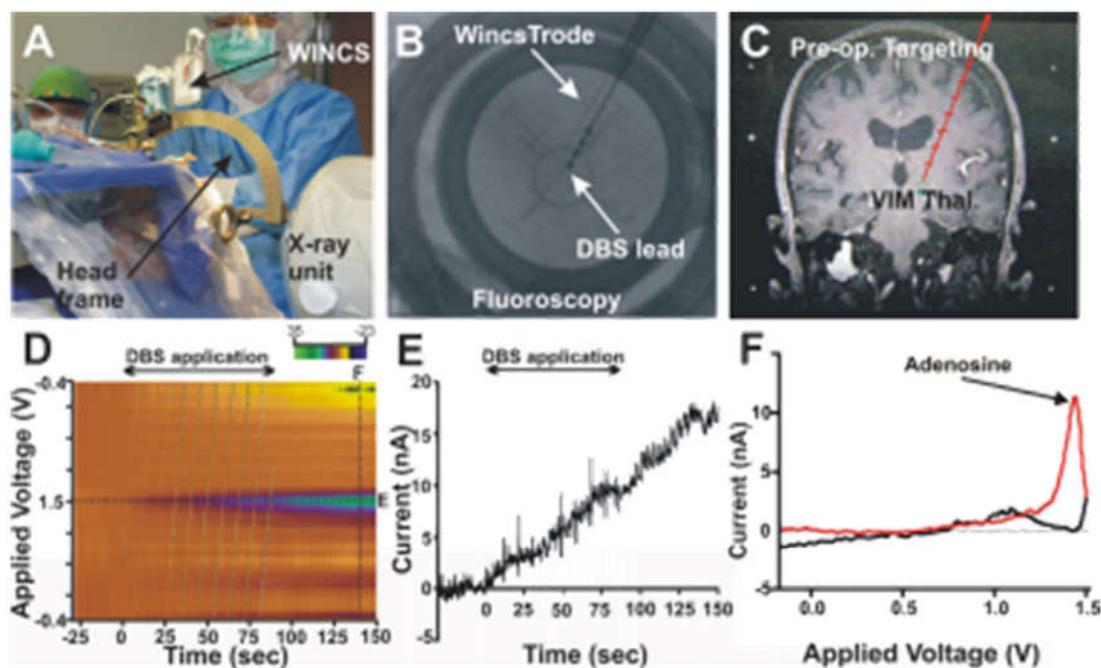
Neurochemical changes evoked by DBS in the VIM of the thalamus in patients with essential tremor. (A) Surgical set-up. (B) X-ray of the position of the human CFM and DBS lead in patient's thalamus. (C) MR image of implantation trajectory. (D) Color plot shows the appearance of oxidation current at +1.4 V immediately upon application of DBS (135 Hz, 60 μ s pulse width, 0.5–2.0 V, slowly increased). (E) Current versus time plot at +1.4 V following DBS. (F) Background subtracted cyclic voltammogram shows the oxidation peak of adenosine at +1.4 V.
